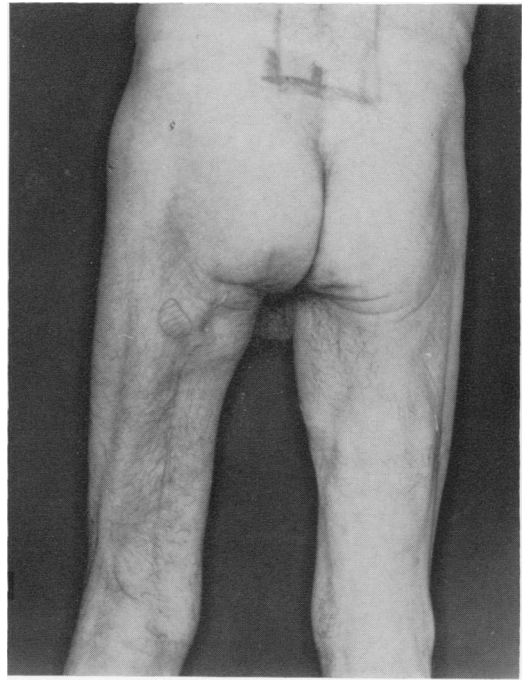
The tumor masses shown in Figure 11 showed partial regression after intra-arterial instillation of nitrogen mustard. However, this regression was extremely short lived. The marked area in the lumbar region shows the size of x-ray port used.
